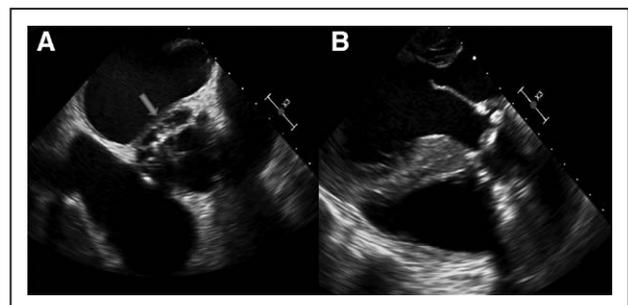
Short axis (A) and long axis (B) of the bioprosthetic aortic valve with surrounding aortic root abscess (blue arrow) as seen on transesophageal echocardiographic images.
